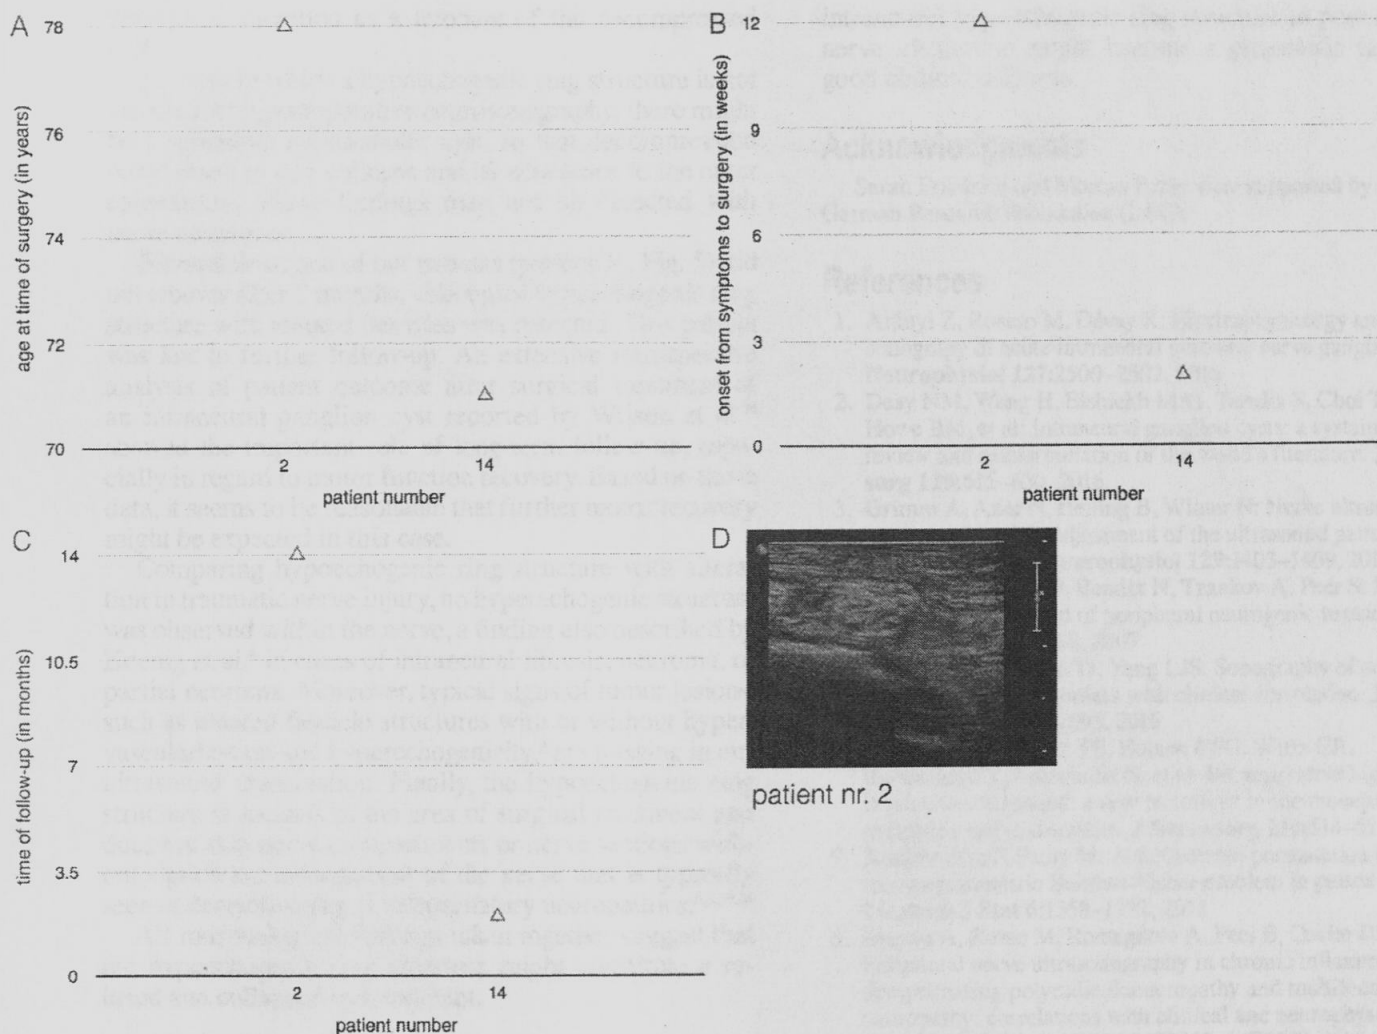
Demographic baseline characteristics of group 2, with patients who had not recovered from impaired motor function at the time of this report. A: Age of patients at the time of surgery. B: Time interval from onset of symptoms to surgery. C: Time of follow-up, when neurosonography and clinical examination were performed. D: An intraneural fibrosis, which could be detected in patient 2, is shown in the neurosonography. Patient number 14, by contrast, showed a hypoechoic ring structure without further nerve damage, but this patient was lost to follow-up 2 months after surgery.
